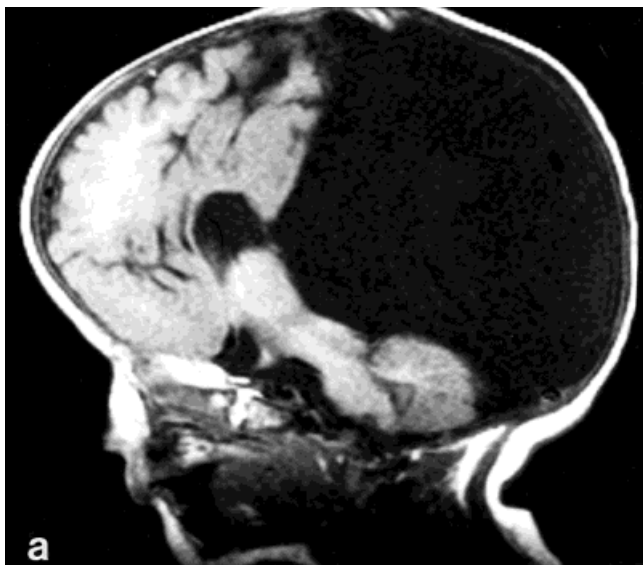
MRI scan of brain at age 7 months, demonstrating (a) large posterior cyst, absence of corpus callosum, and abnormal gyral pattern in frontal lobes and (b) absence of orbits bilaterally.
